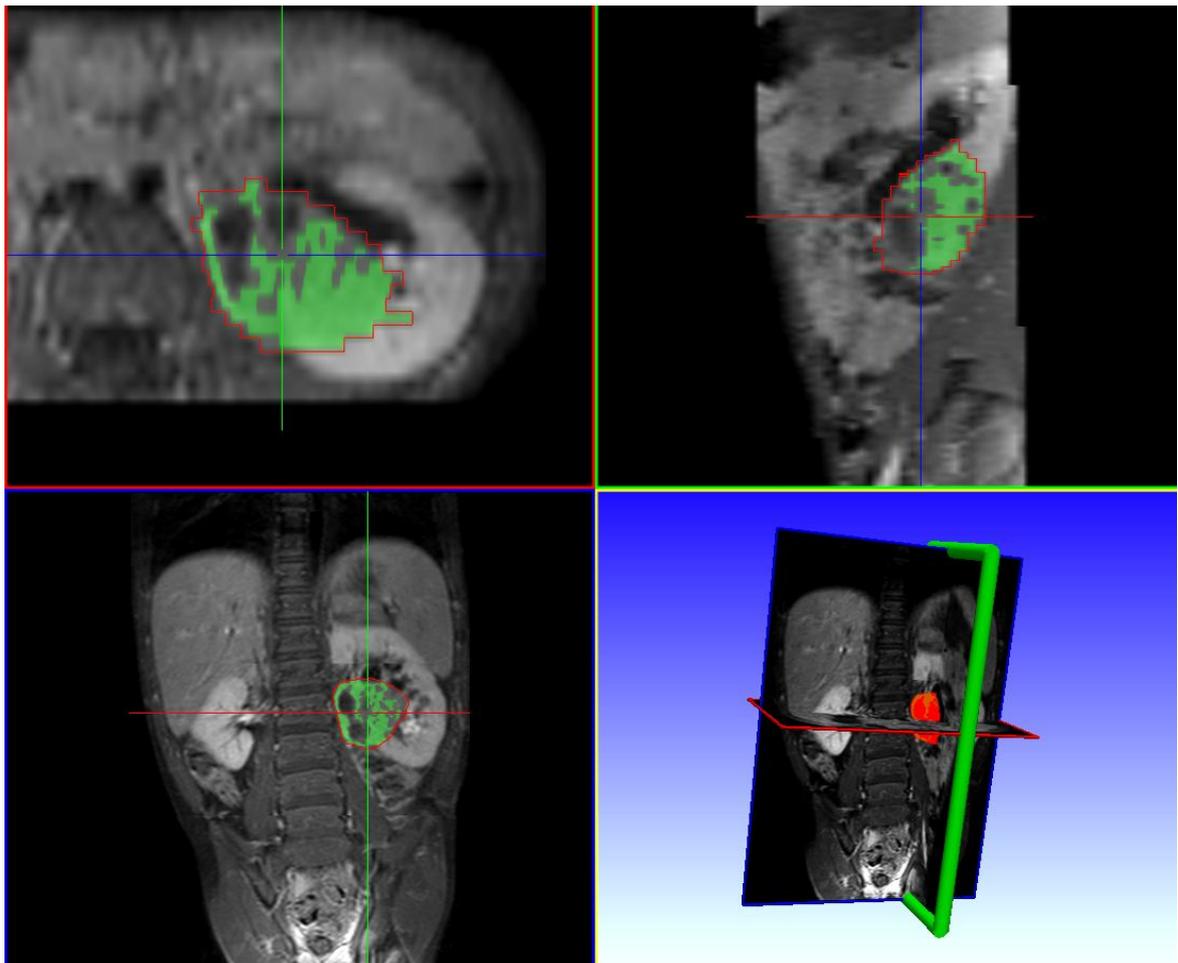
Automated division of living (green) and abnormal tumour tissue in MRI using an intensity based estimation
